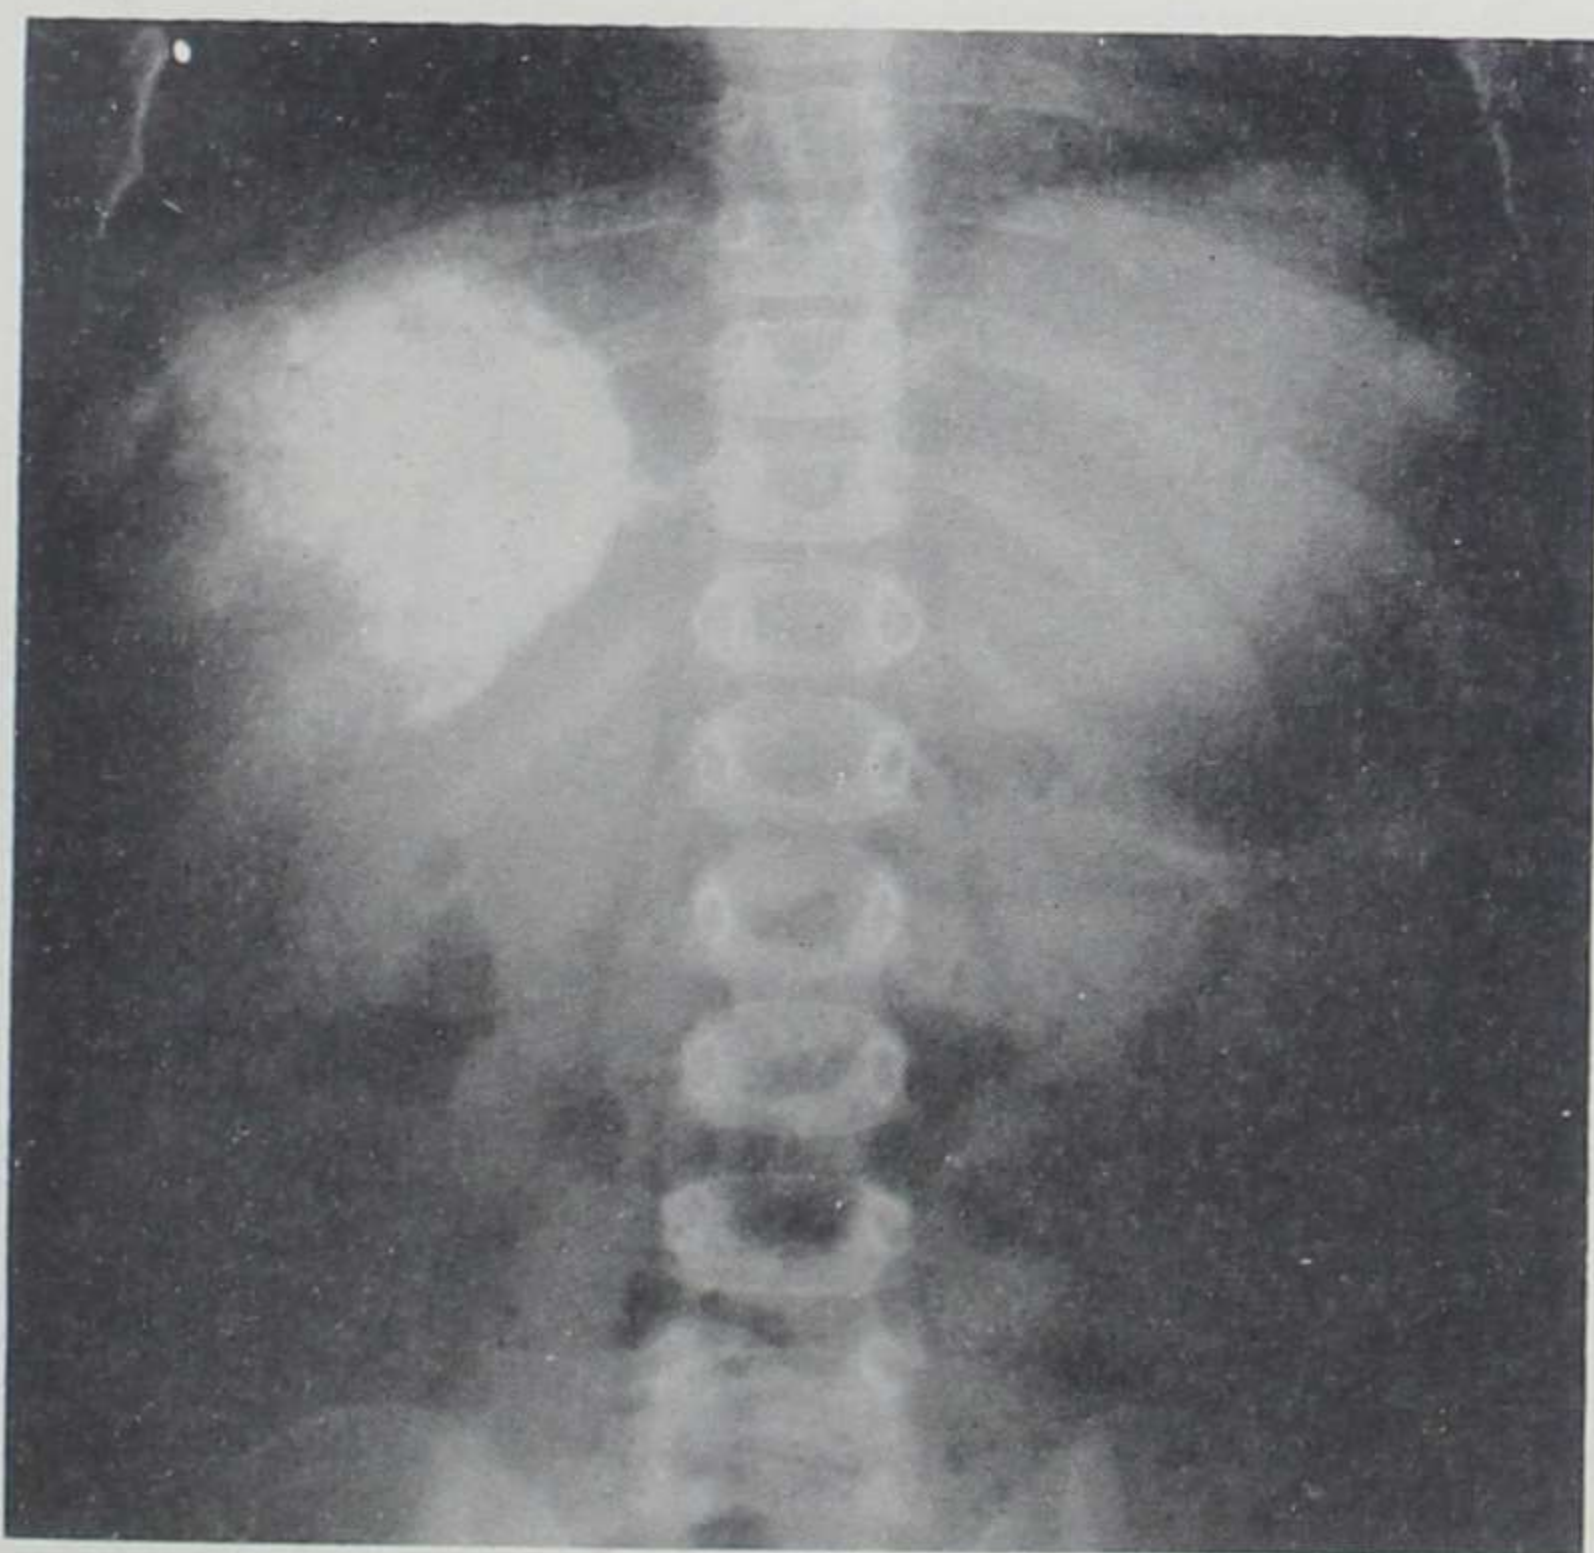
X-ray of abdomen showing large calcified mass in position of right lobe of liver. (Courtesy of Wilkins, L., and Ravitch, M. M.: *Pediatrics* 9:671-681, June, 1952.)
